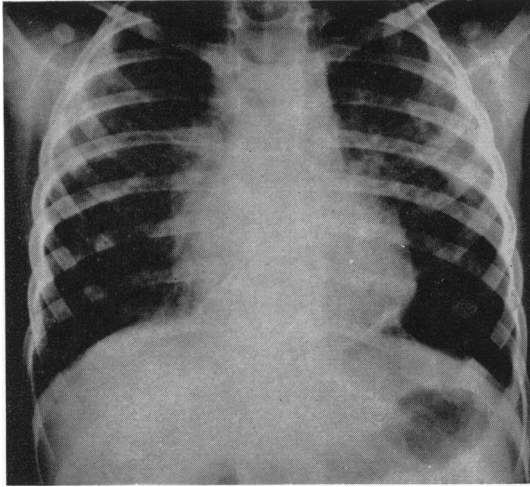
Radiograph of the chest.
